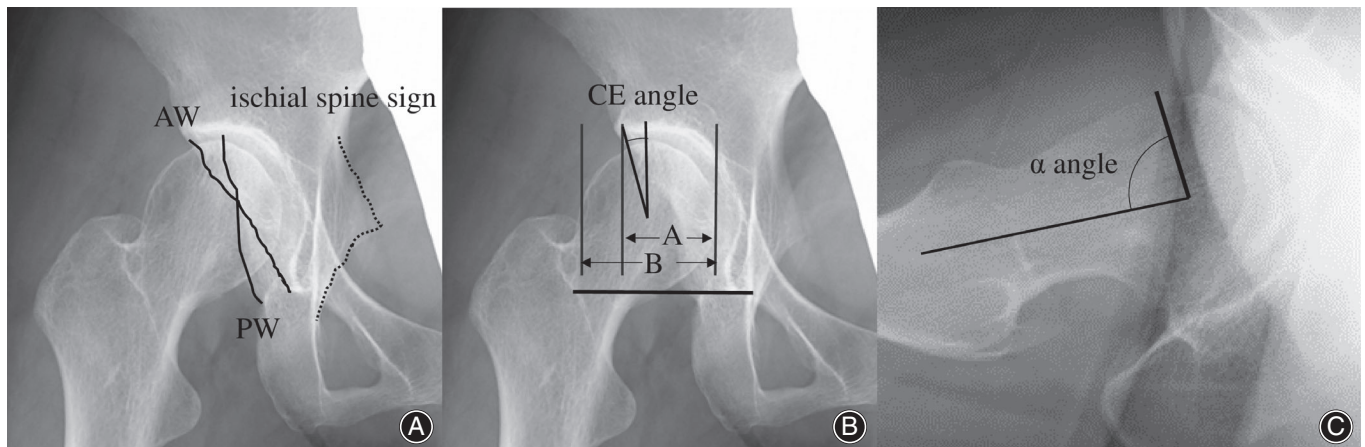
Preoperative radiographs. The patient experienced right hip joint pain with developmental dysplasia of the hip and femoroacetabular impingement owing to acetabular retroversion. (A) Image of the right hip joint indicating Kellgren–Lawrence classification grade 1 and showing a center edge (CE) angle of 18° and acetabular head index (AHI) of 69%. (B) Image of the right hip joint showing retroversion of the right hip acetabulum as indicated by a positive cross-over sign (dotted line) and ischial spine sign (black arrow) (C) Cross table lateral radiograph of the right hip joint showing an α angle of 72.9° . AW, anterior wall; PW, posterior wall; AHI, $A/B \times 100$.
